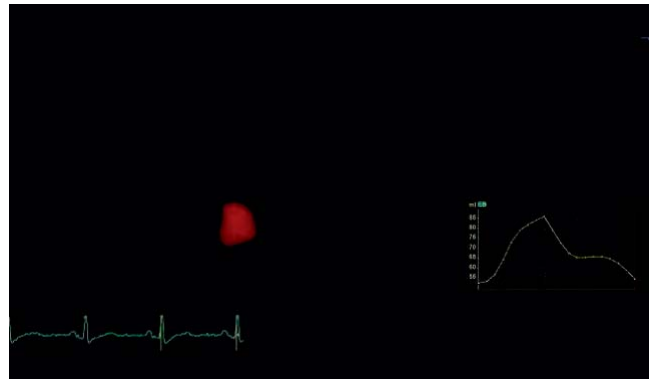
3D echocardiographic evaluation of left atrium-the 3D LA reconstructed volume.
